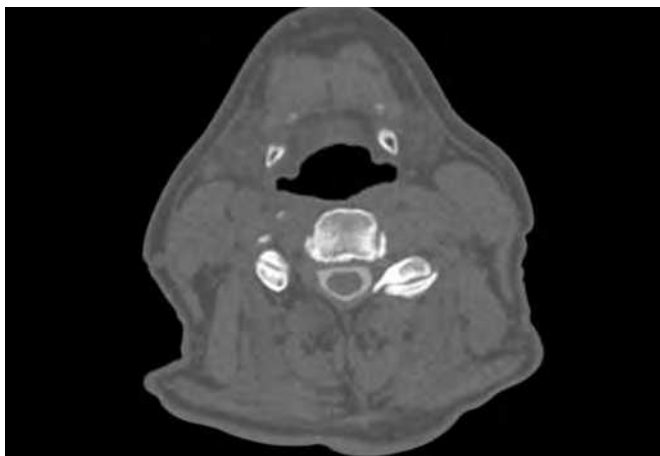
The postoperative axial CT image after right C7-T1 foraminotomy.
